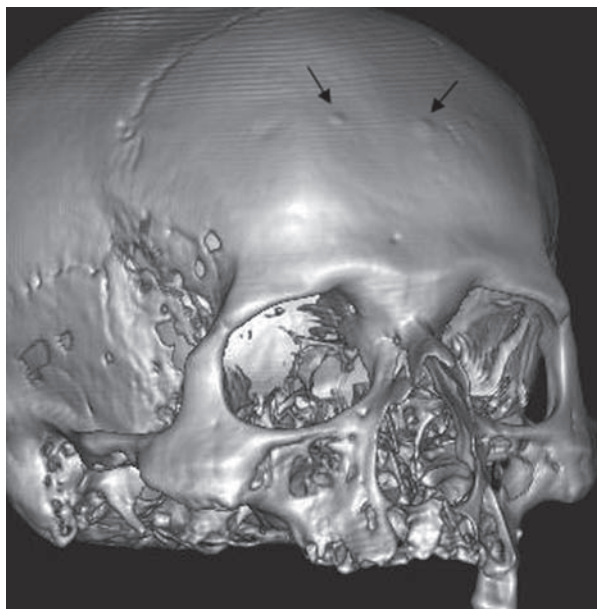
CT images of a skull from Sarigo necropolis. We can note several osteomas on the frontal bone.
